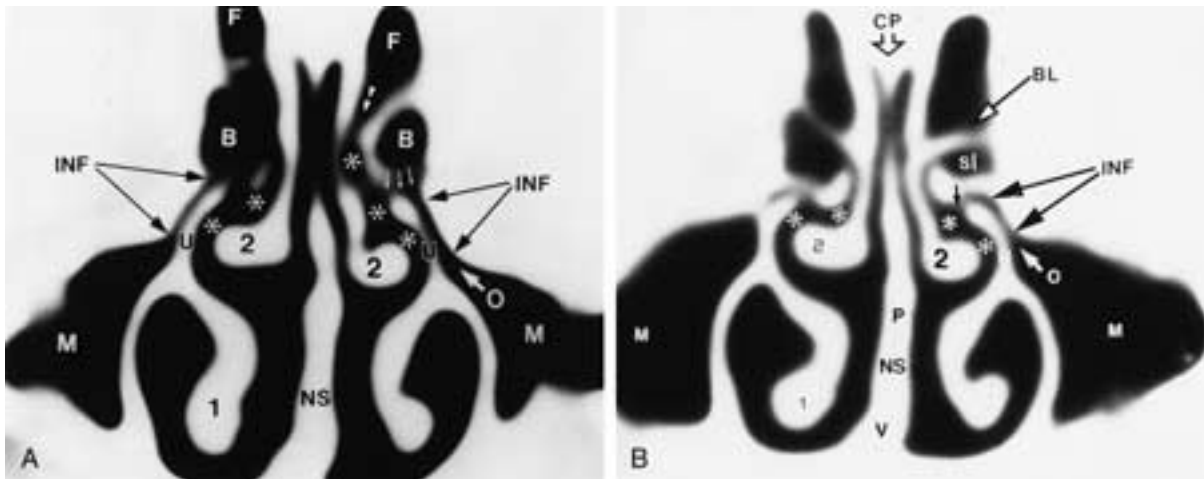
Anterior ostiomeatal channels. Coronal CT images through the anterior ethmoid sinuses show the air passages communicating with the frontal sinus (F), anterior ethmoid sinus, and maxillary sinus (M). The primary ostium (O) of the maxillary sinus communicates with the infundibulum (INF). The infundibulum is bordered medially by the uncinate process (U) and laterally by the orbit. In turn, the infundibulum communicates with the middle meatus (asterisks) through the hiatus semilunaris (most medial white arrows in A, small black arrow in B). The frontal recess (white arrowheads) is patent. The ethmoid bulla (B) is usually the largest air cell in the anterior ethmoid sinus. Note the vertical attachment of the middle turbinate (2) to the cribriform plate (CP) and its lateral attachment to the lamina papyracea, the basal lamella (BL). The air space between the basal lamella and the ethmoid bulla is the sinus lateralis (sl). Inferior turbinate (1), nasal septum (NS), vomer (V), and perpendicular plate of the ethmoid bone (P).
